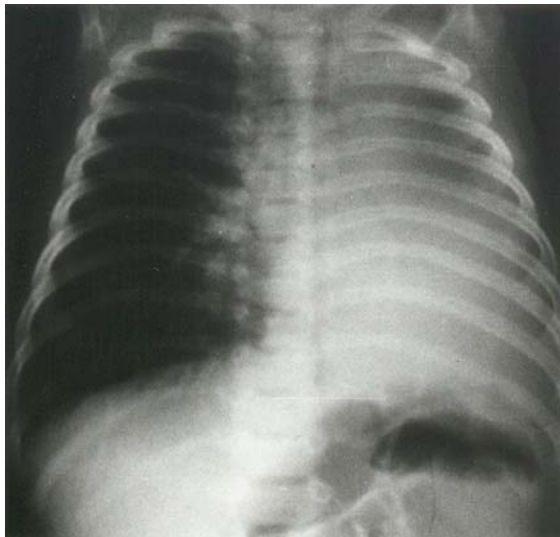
Pre-procedure chest radiograph showing atelectasis of the left lung.
